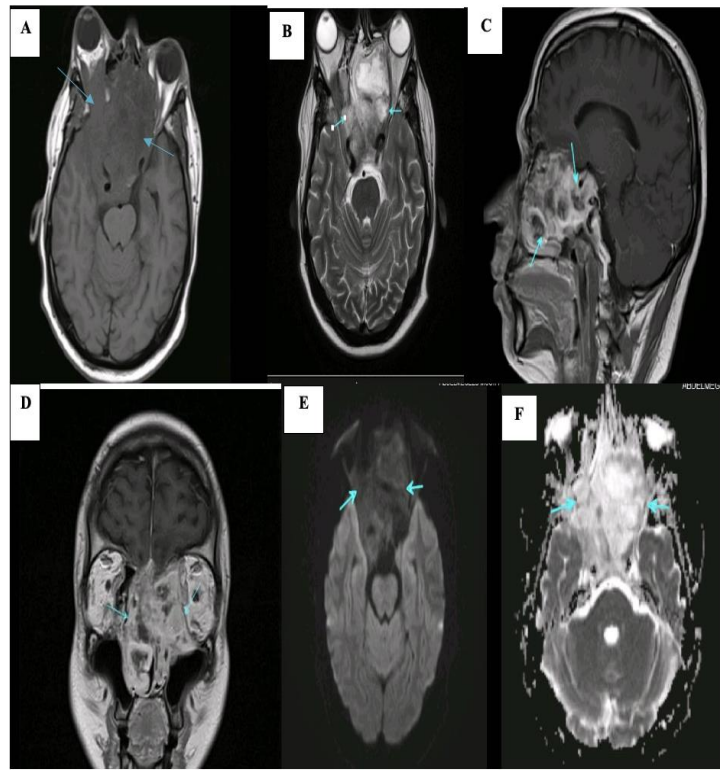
MRI findings in male patient aged 37 years presented with epistaxis and headache. (A) Axial cut T1W and (B) T2W show abnormal signal intensity large destructive lesion infiltrating the fronto-ethmoidal and sphenoidal sinuses with Rt orbital and nasal extension (arrows) (C) and (D) Contrast- enhanced sagittal and coronal cuts display moderate heterogeneous enhancement(arrows) (E) and (F) DWI and ADC map images show scanty areas of restricted diffusion (arrows) and low ADC value ($0.73 \times 10^{-3} \text{ mm}^2 / \text{S}$), pathologically proved Sino nasal SCC.
